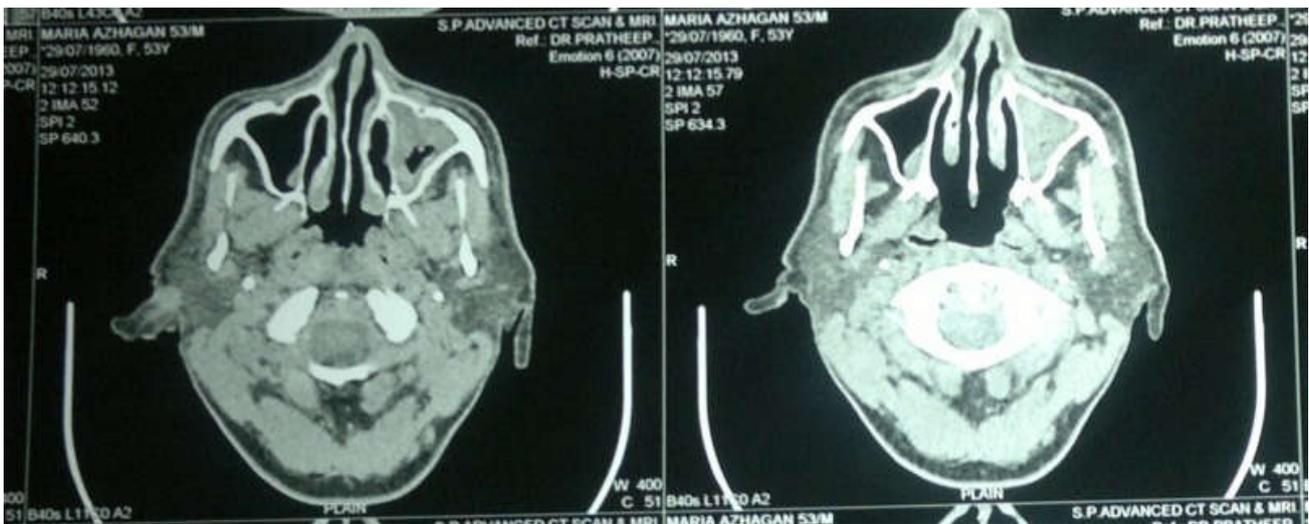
Axial CT showing extend of lesion in to the left maxillary sinus
